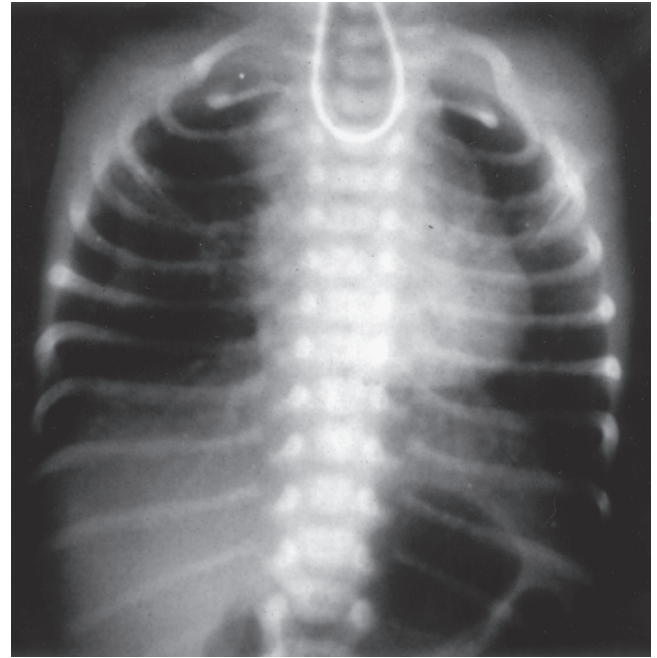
■ Chest radiograph of a patient with esophageal atresia and tracheoesophageal fistula. Note the catheter curved in the upper pouch and the presence of air in the intestinal tract. (Courtesy Dr. R. Ricketts, Emory University Medical Center.)
